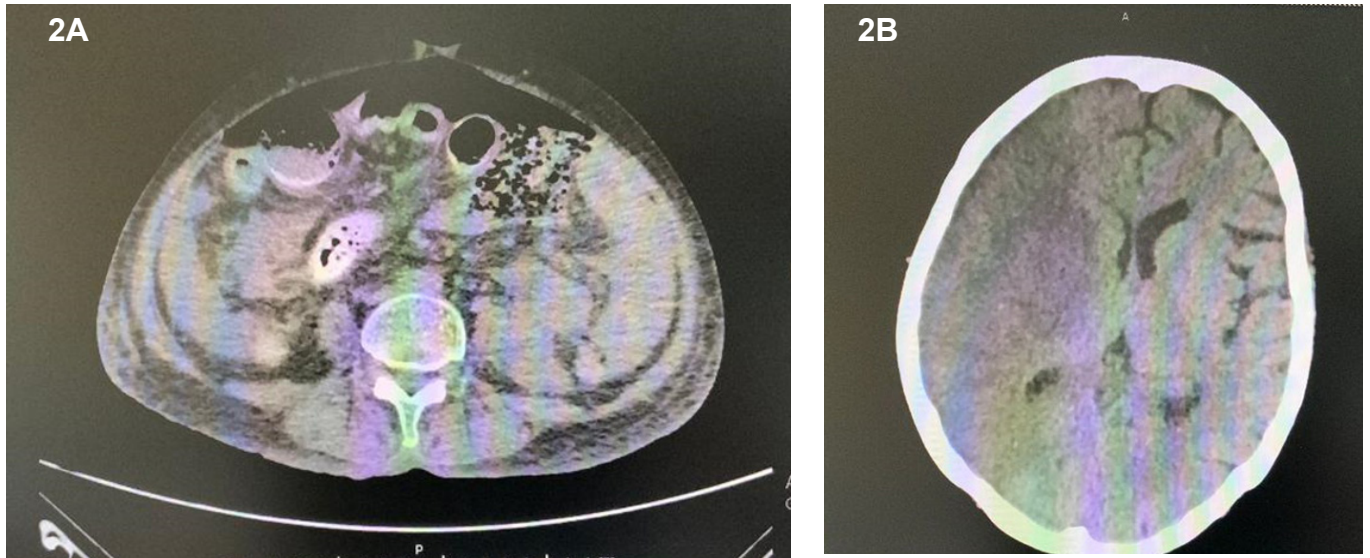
Contrast enhanced CT of the abdomen showing free air representing pneumoperitoneum and disrupted wall of ileum.
